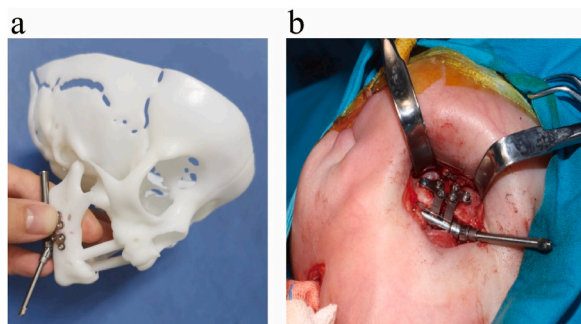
The preoperative planning and the operation. (a) Before MDO surgery, a 3-dimensional model of skull and craniofacial was established using CT data, and virtual surgical planning was made. (b) Individualized internal mandibular distractors were fixed during surgery.
